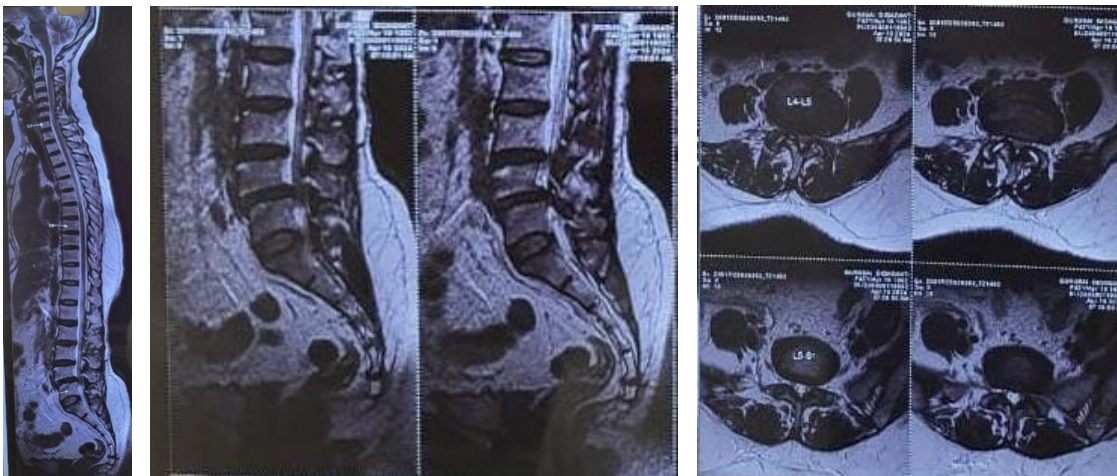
79 Pre Op MRI showing L4-L5 Degenerative Spondylolisthesis
